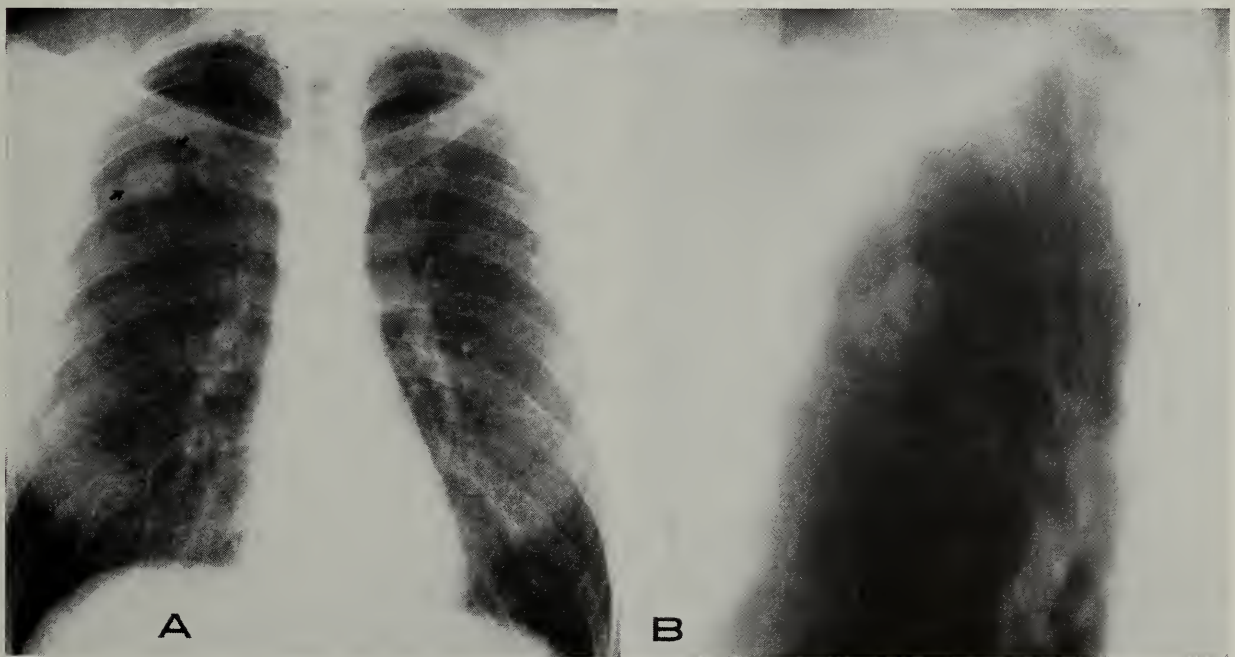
The patient, a 30-year-old white man had a chest roentgenograph because of a minor injury to the right shoulder. It showed (A) a "coin lesion" in the right upper lobe, with no other abnormalities. Figure B is a frontal tomogram of the lesion. Except for minor pain due to the trauma, the patient was asymptomatic. He had lived in the San Joaquin Valley two and a half years earlier. Complete work-up, including bronchoscopy, sputa for fungi, and coccidioidin skin tests were all negative. Thoracotomy revealed a nodule in the right upper lobe which contained spherules with endospores and septate hyphae which on culture yielded *C. immitis*.
